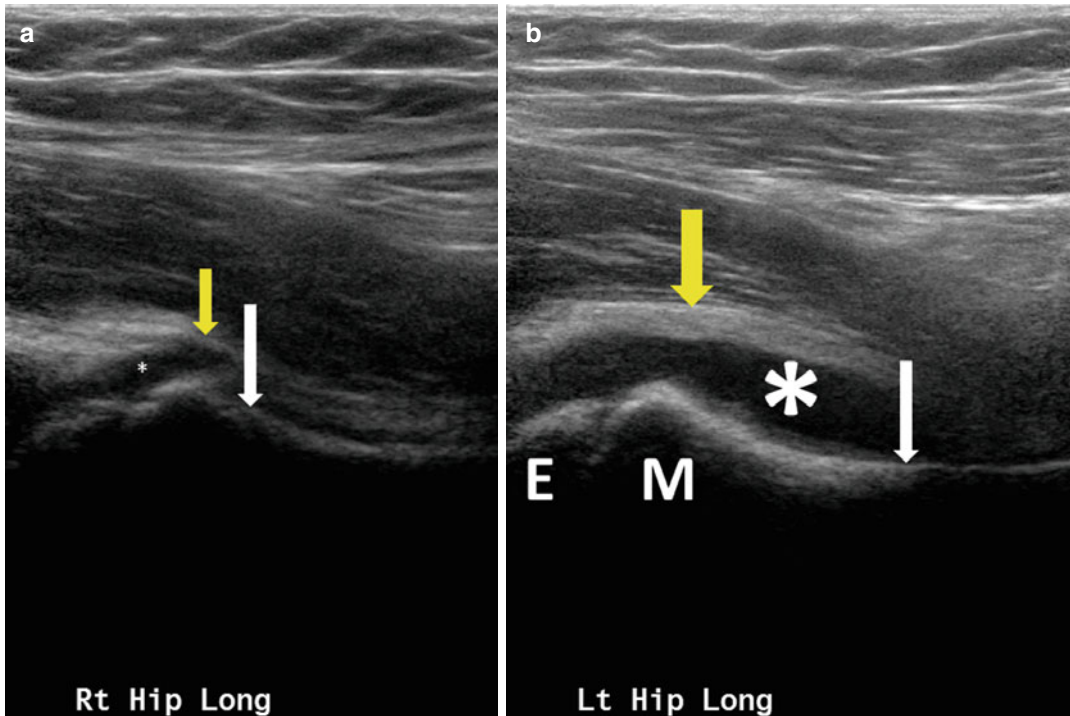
A hip ultrasound of a child with toxic synovitis. The right hip is the normal hip, and the left hip is the one with toxic synovitis. The joint fluid is marked by the *asterisk*, the hip capsule by the *yellow arrow*, and the anterior
